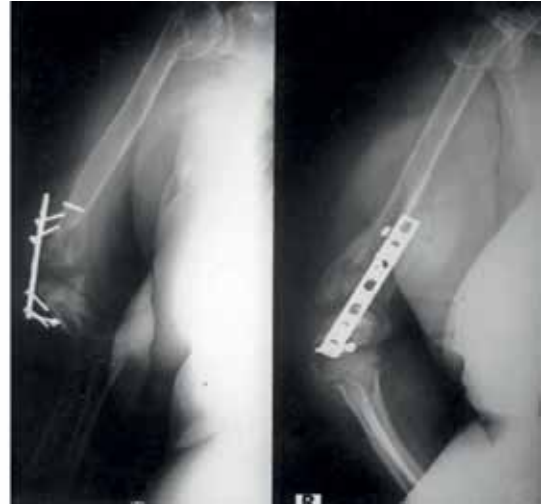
Radiographic view. Implant failure of right humerus
